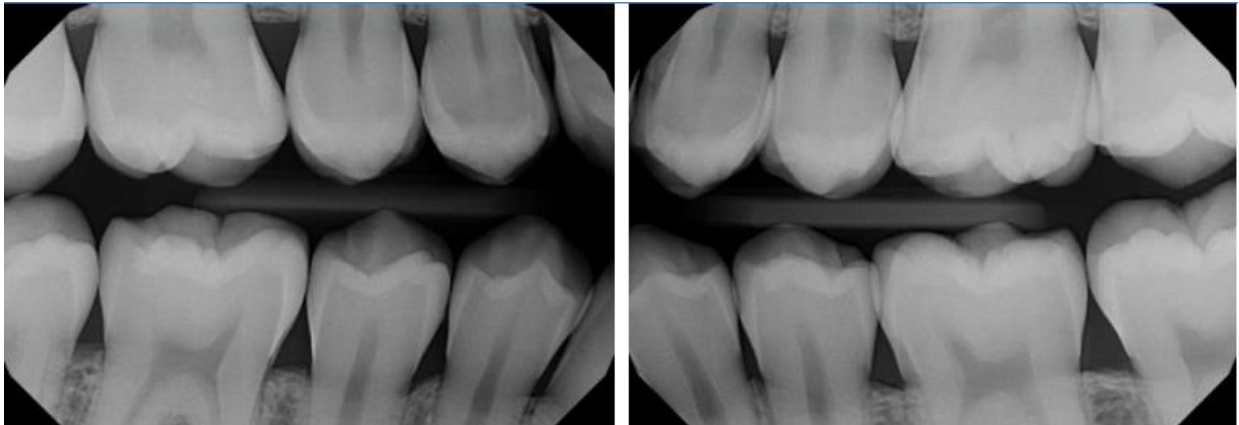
Pre-existing (on file) bitewing radiographs taken 6 months prior to injury:
